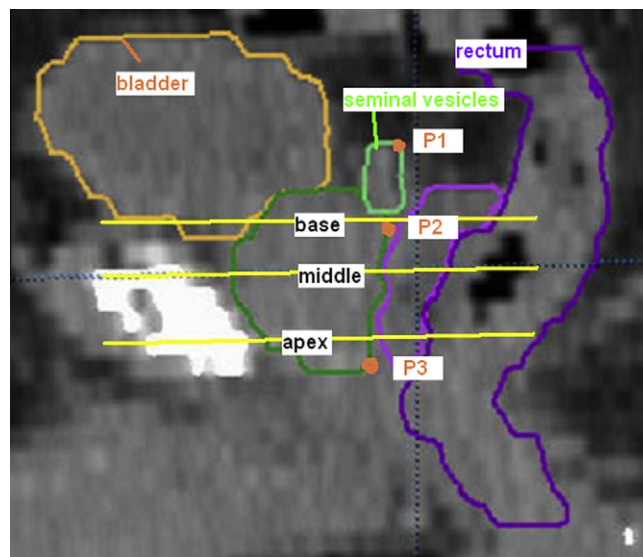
Sagittal CT reconstruction demonstrating the definition of the levels of the base, middle and apex, as well as the points P1 (superior prostate/seminal vesicle), P2 (level of the bladder neck) and P3 (inferior prostate).
